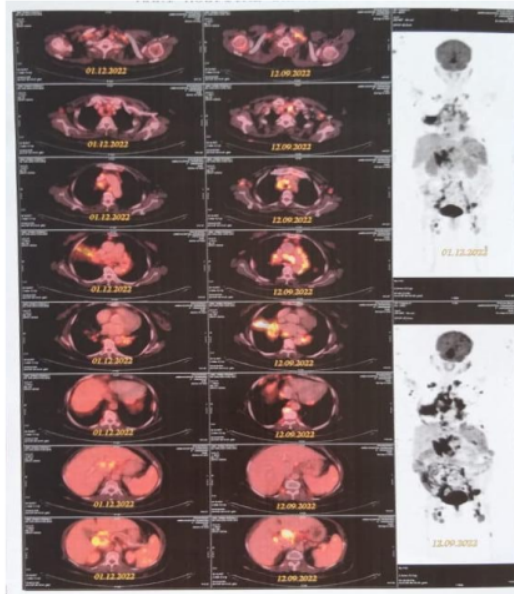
Follow-Up Whole-Body PET-CT Scan
